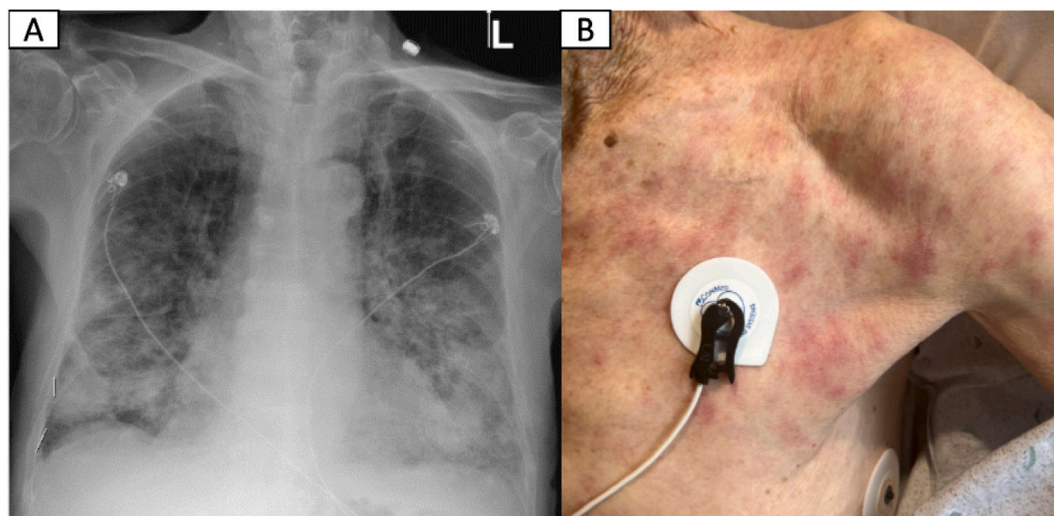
A: Chest X-ray on admission. B: Subacute rash in chest and arms.
